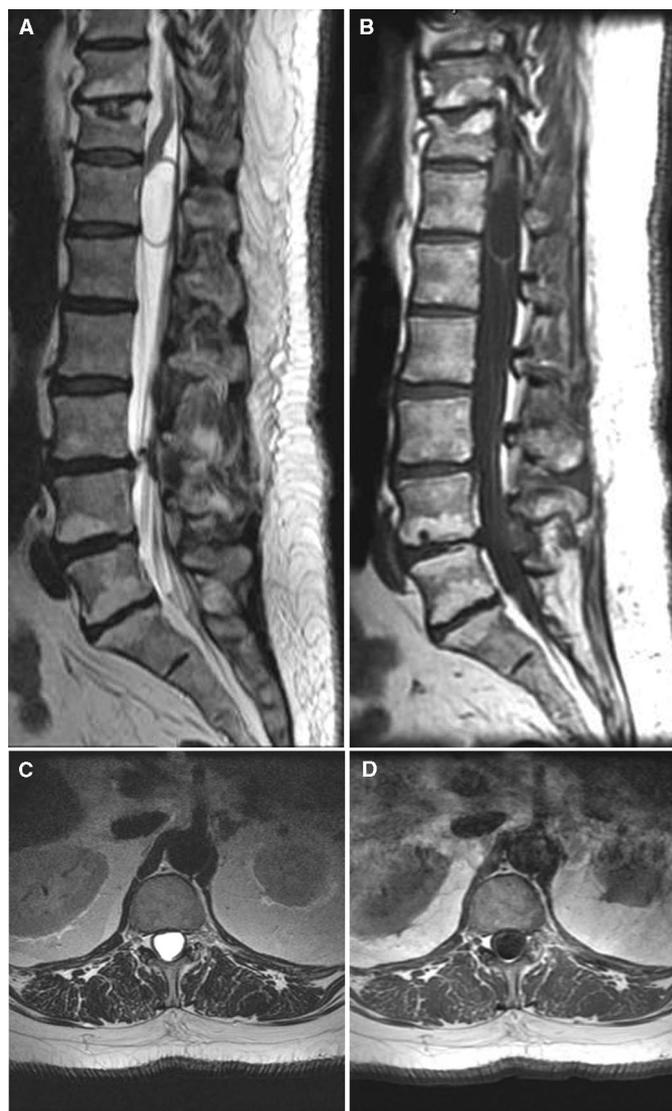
Sagittal T2- (A) and T1-weighted (B) MRI images displaying a cystic cavity in the region of the conus medullaris. Although the T2-weighted image suggests an intramedullary lesion pushing the conus forward, the T1-weighted image shows the filum terminale emanating from the center of the caudal portion of the cyst, more suggestive of a CDVT. Axial T2-weighted (C) and T1-weighted (D) MRI images confirm the intra-axial cyst at the level of the conus. Notice that the cyst fluid is similar to that of cerebrospinal fluid on all sequences.
